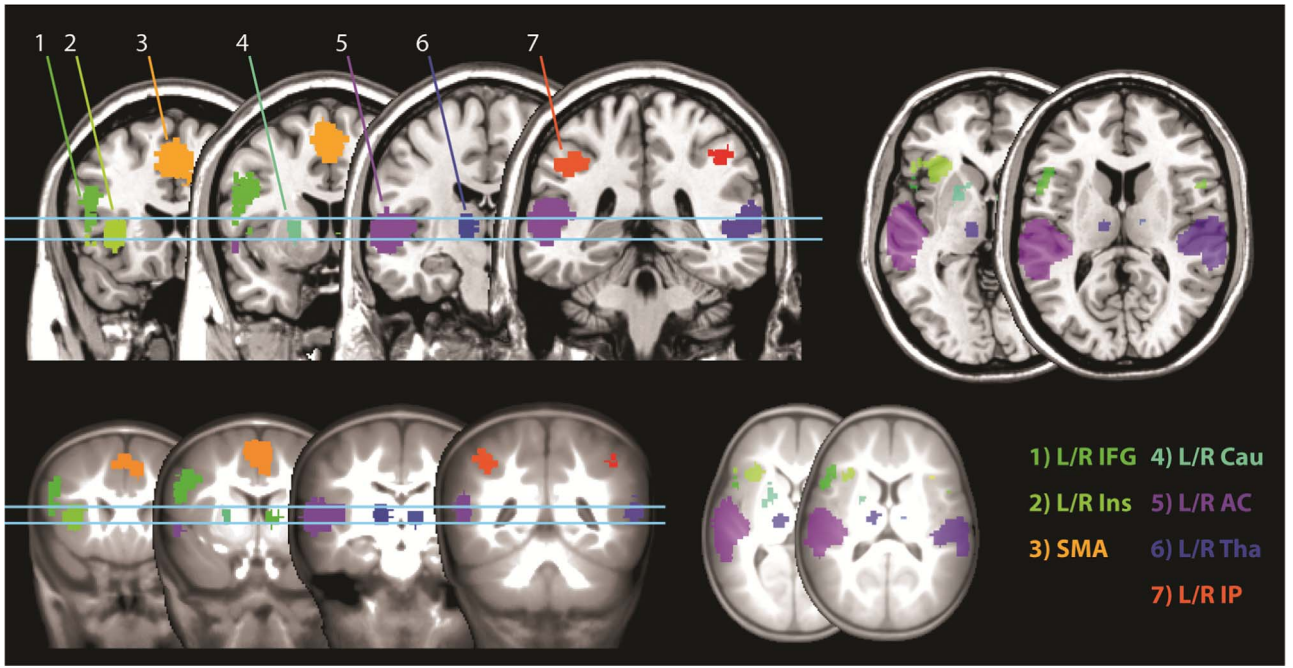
Regions of Interest (ROIs) derived from a Neurosynth reverse inference map of the term “speech”, overlaid on the adult MNI template T1-weighted structural image (top), and the 1-year old UNC infant template (bottom). Horizontal blue lines across coronal slices indicate the position of the axial slices. L/R – Left/Right; IFG – Inferior Frontal Gyrus; Ins – Insula; SMA – Supplementary Motor Area; Cau – Caudate; AC – Auditory Cortex; Tha – Thalamus; IP – Inferior Parietal. Not shown: left and right cerebellum.
